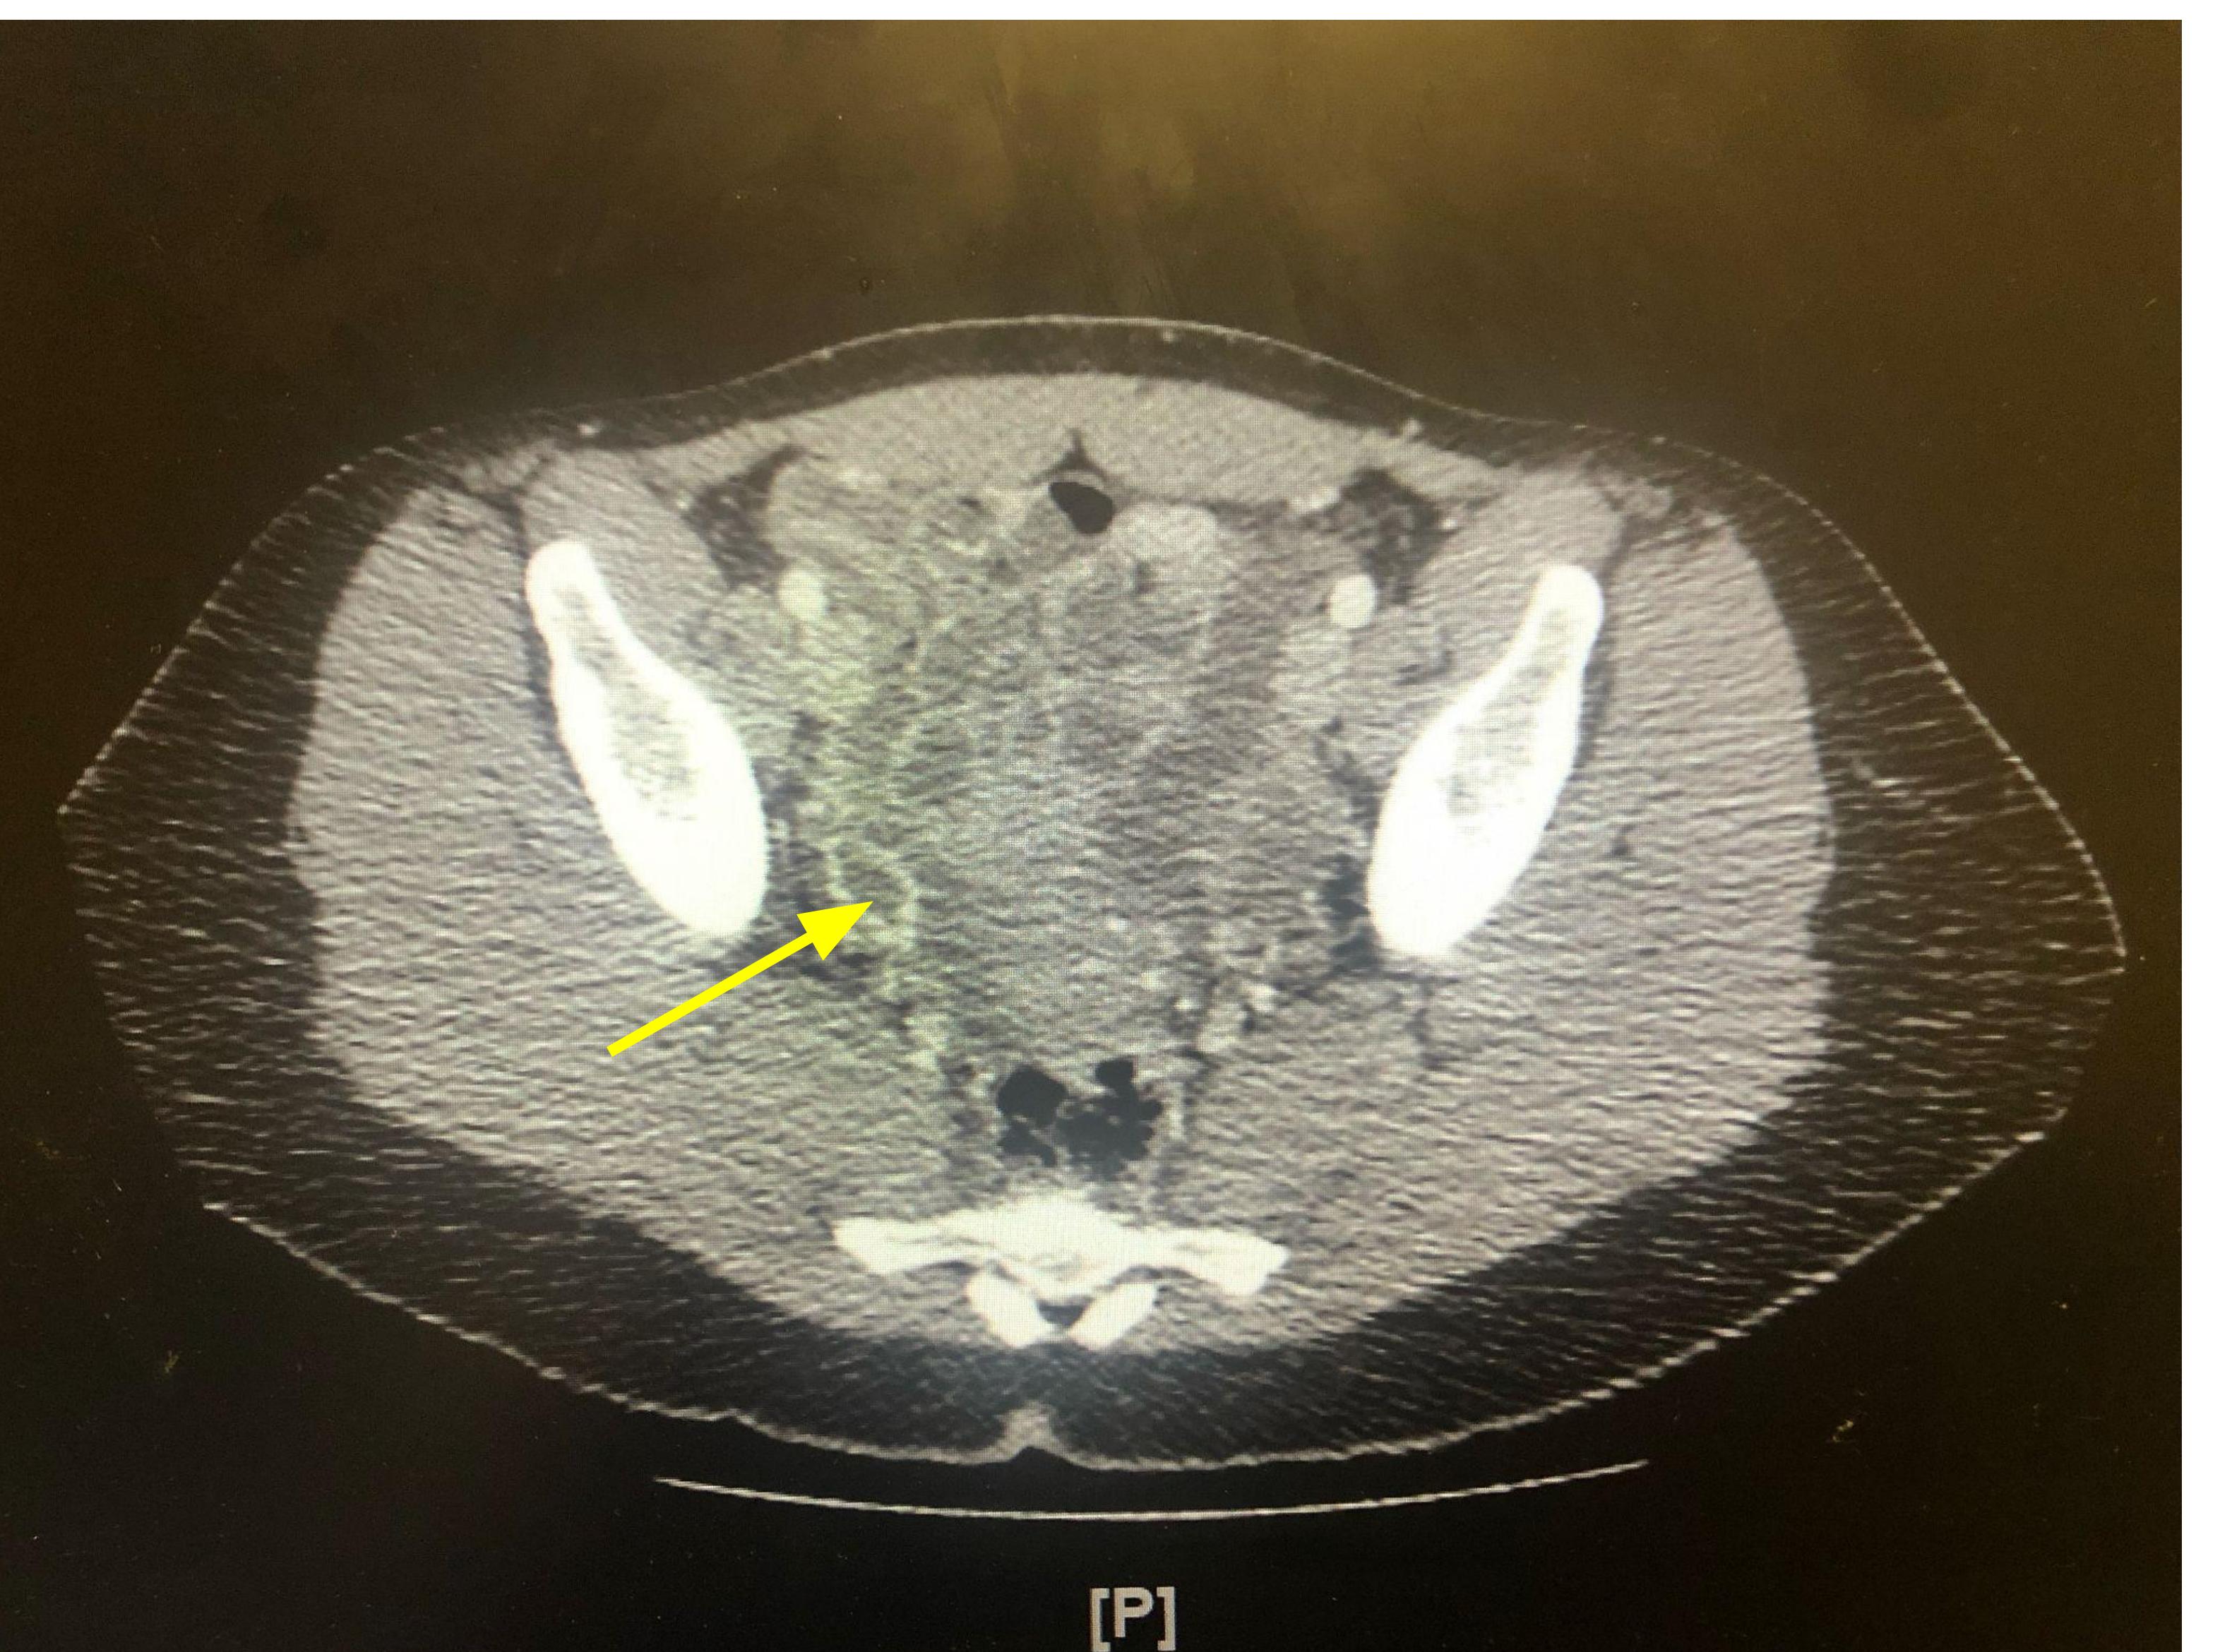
CT abdomen and pelvis demonstrating crenulated right ovarian lesion (indicated by yellow arrow) measuring $2.5 \times 1.6 \text{ cm}$.
